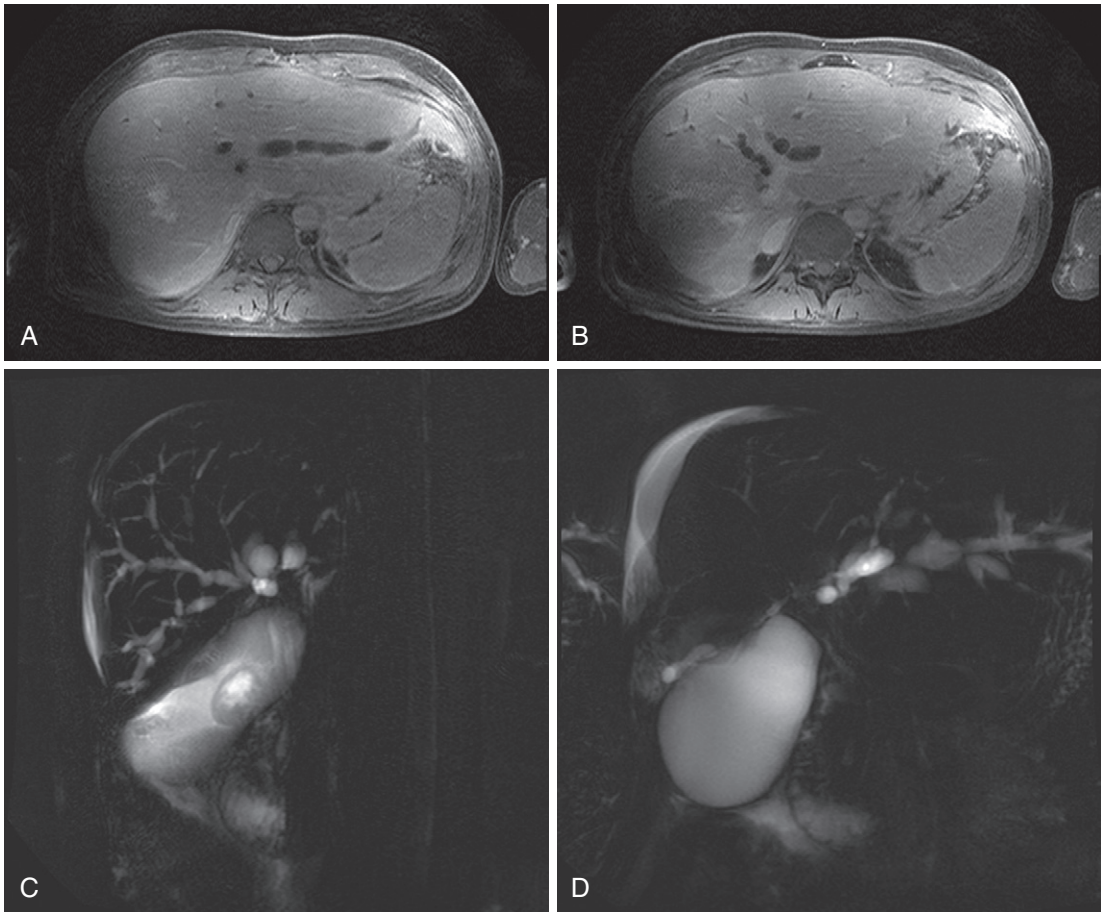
Rectangular field of view. Axial T1-weighted enhanced images (A and B) performed on a 3-Tesla system with a relatively large square field of view—adding time-consuming phase-encoding steps to cover air over the patient—in a patient with primary sclerosing cholangitis reveal irregular beaded biliary ductal dilatation and structuring as corroborated on the corresponding magnetic resonance cholangiopancreatography (MRCP) images (C and D).
